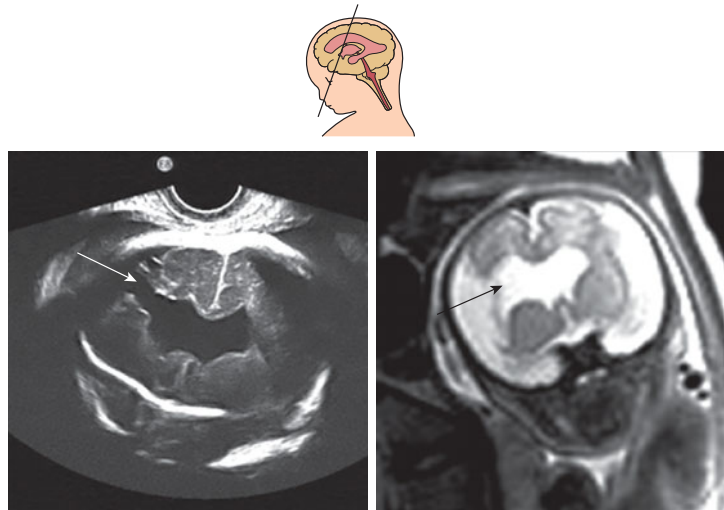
Comparison of US (*left*) and MRI (*right*) of a right-sided, open-lip schizencephaly. The arrows point to the cleft.
